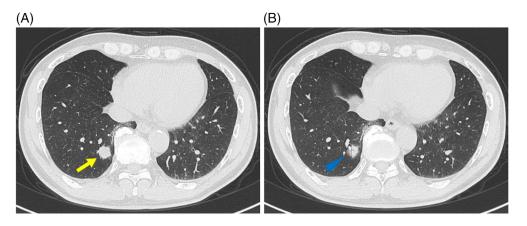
(A) Chest CT scan revealing a lobular solid nodule with a maximum diameter of 1.9 cm in the lower lobe of the right lung. (B) The arrowhead indicates an air bronchogram on the lower edge of the nodule
